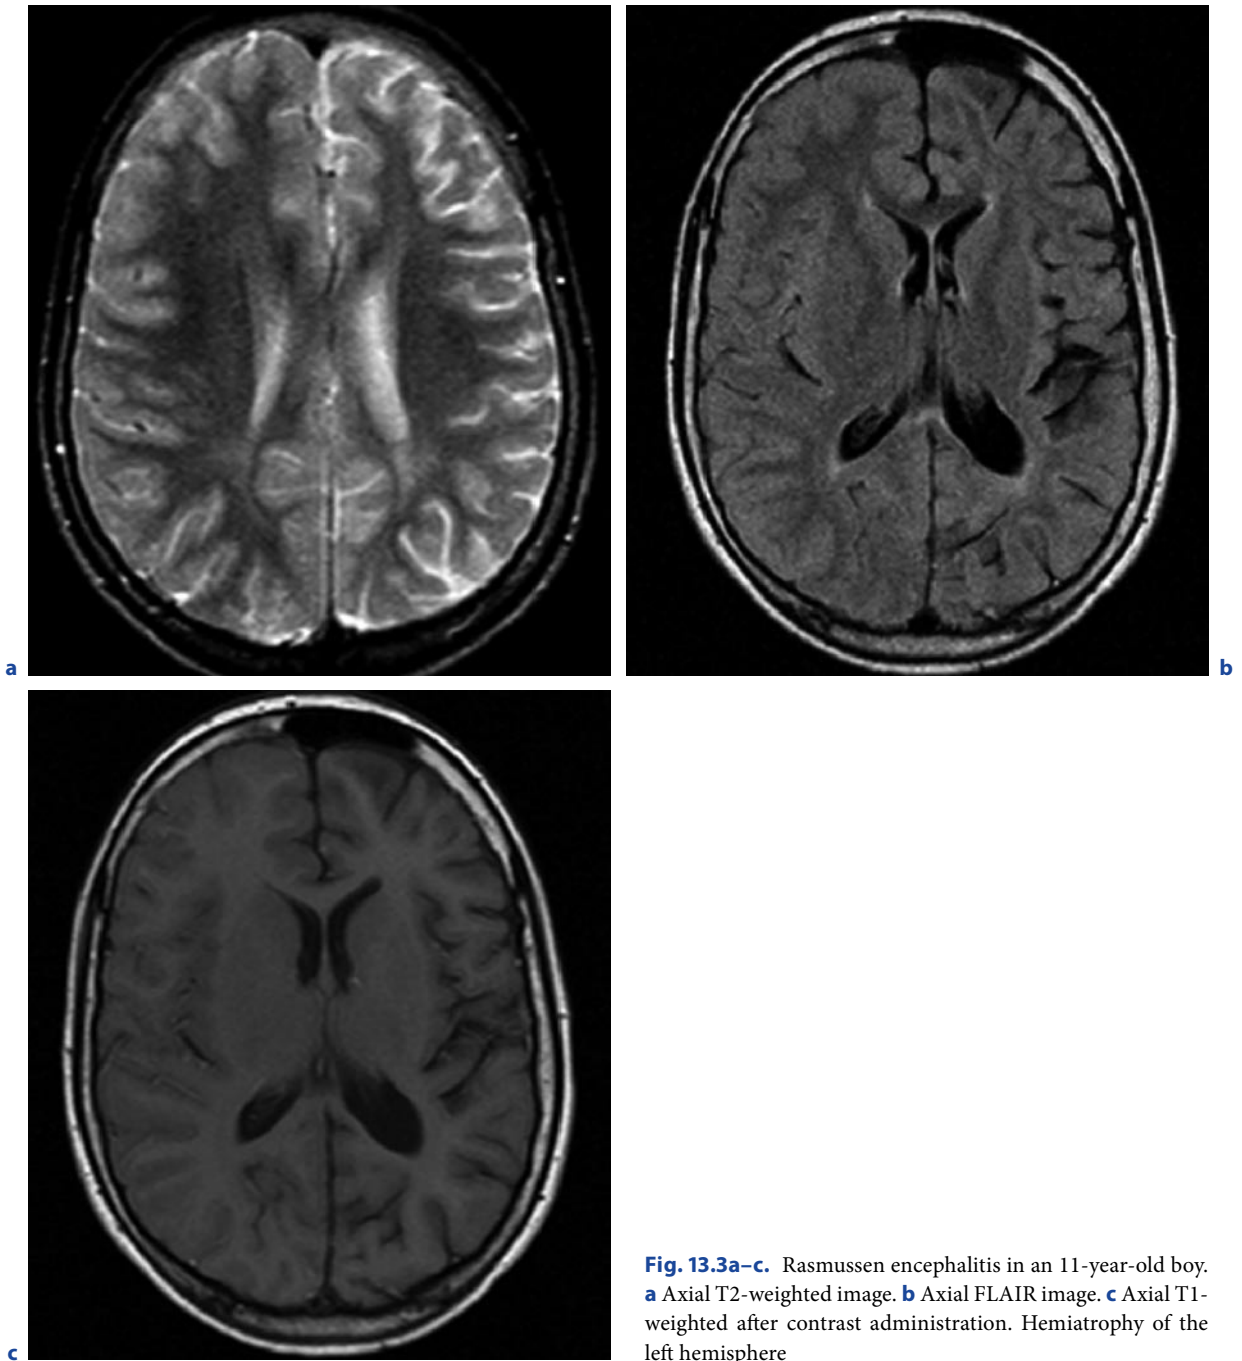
Rasmussen encephalitis in an 11-year-old boy. a Axial T2-weighted image. b Axial FLAIR image. c Axial T1-weighted after contrast administration. Hemiatrophy of the left hemisphere
